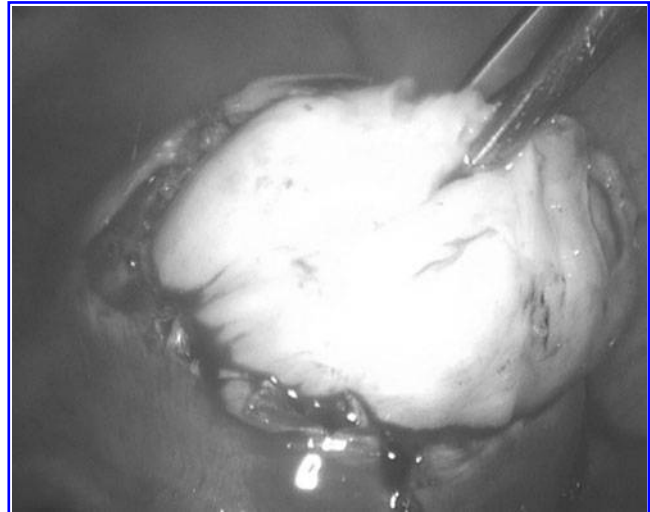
Laparoscopic picture depicting the dissection of the myoma. Taken from ISBN: HB 9781107029743. Edited by Botros R.M.B. Rizk and Elizabeth Puscheck. Ultrasonography in Gynecology. Figure 16 in the book chapter "Transvaginal ultrasound scan findings of uterine fibroid effect on treatment plan." By Dr. Mostafa Abuzeid and Salem Joseph. Copyright © 2012 Cambridge University Press. Reprinted with the permission of Cambridge University Press.
